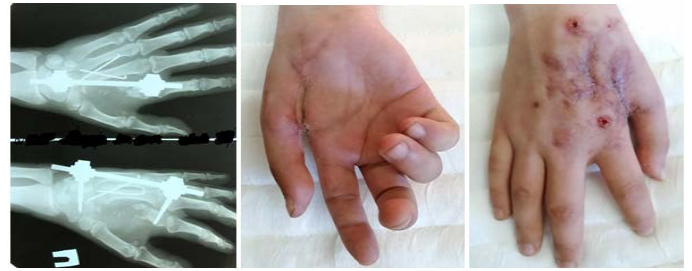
X-rays and the appearance of patient K's hand during the removal of the external fixation device.
